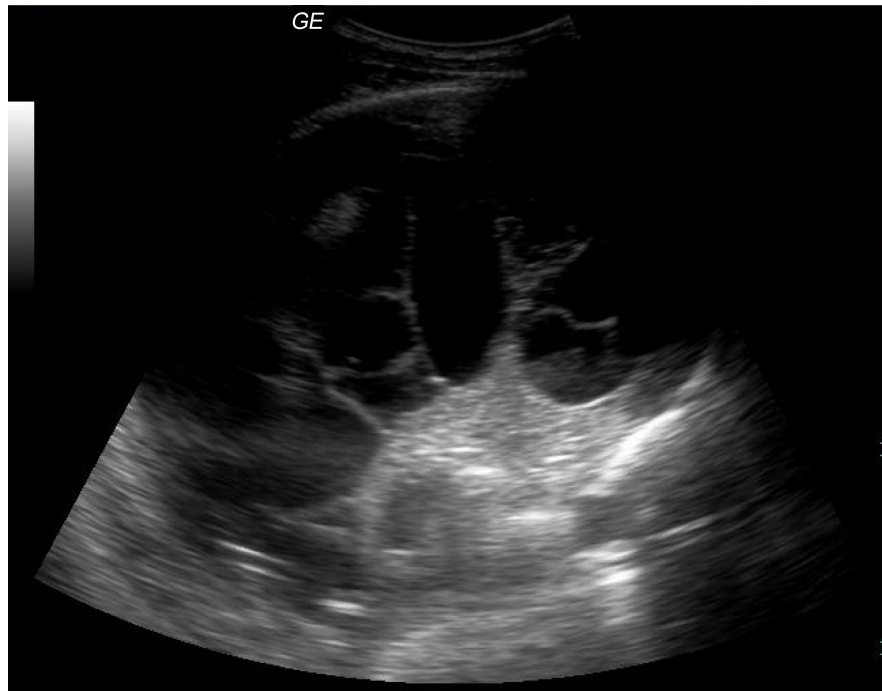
Sonographic septation.
